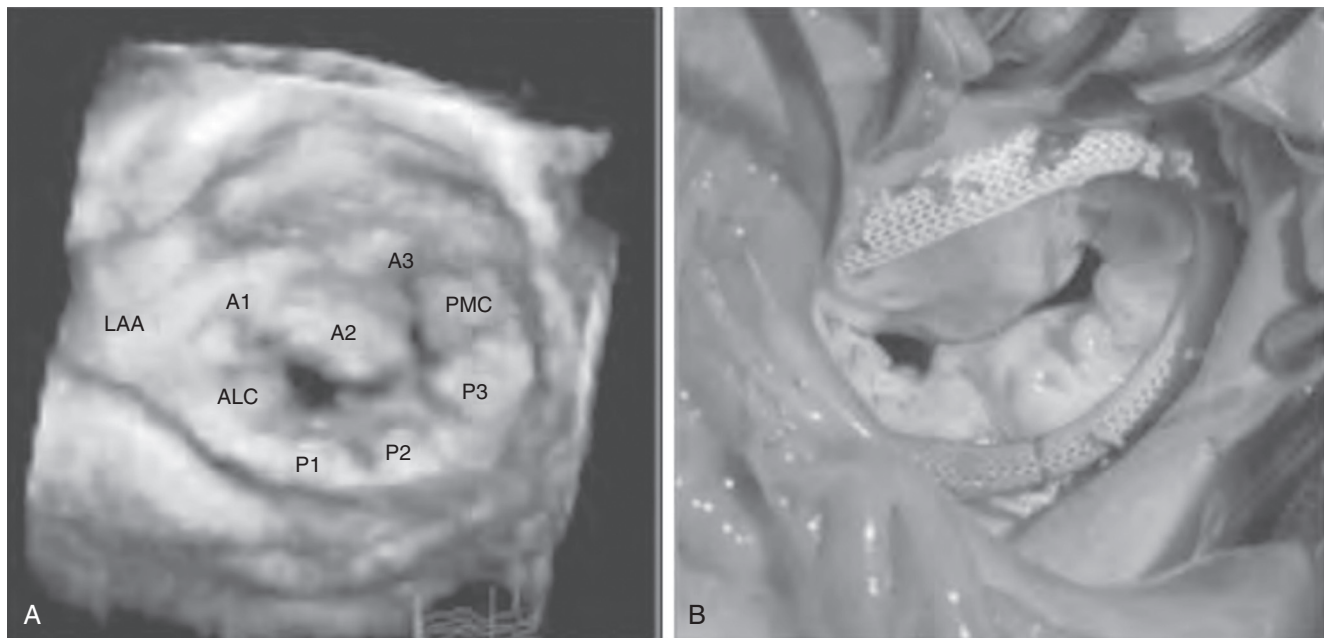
■ Segmental anatomy of the mitral valve from the surgical view is demonstrated (A) grossly and (B) with three-dimensional transesophageal echocardiography. (Modified from Debonnaire P, Palmen M, Marsan NA, et al: Contemporary imaging of normal mitral valve anatomy and function. *Curr Opin Cardiol* 27:457, 2012.)
